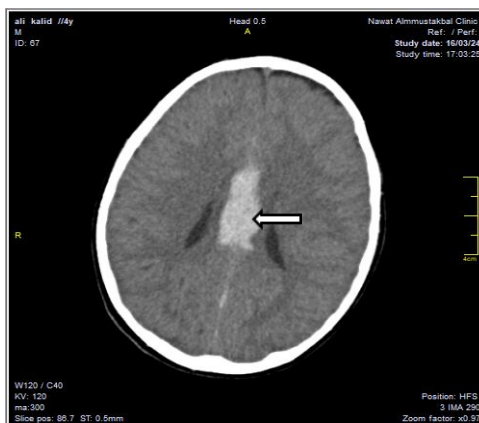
Brain CT showed a clear interhemispheric hematoma on the corpus callosum, causing neurological disorientation.
